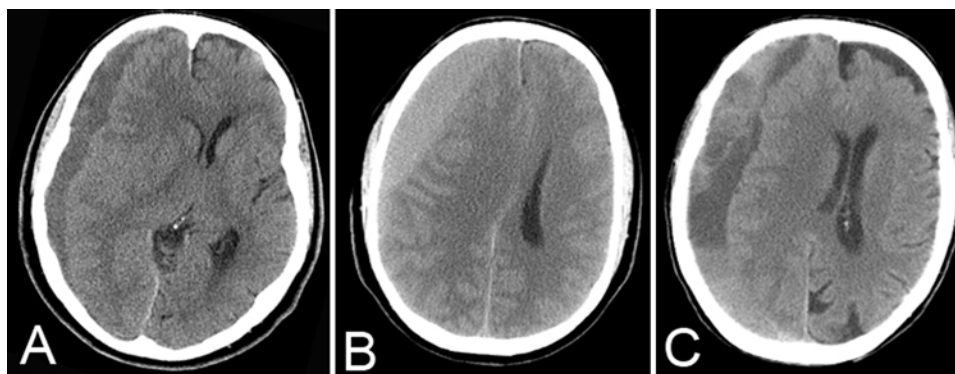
Axial cranial CT scans demonstrating differing density collections. A: Right hypodense SDH. B: Right isodense SDH. C: Right mixed density SDH.
